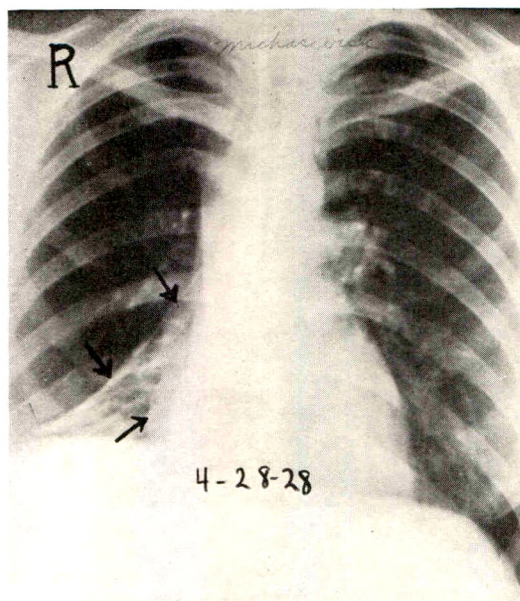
Roentgenogram of Case II taken fourteen months after Figure 4. Outer row of arrows indicates lateral border of thickened pleura representing the residue of the mediastinal empyema. Inner arrow shows right heart border. This is now a dry pleurisy and shows no change from film taken two months previously.
